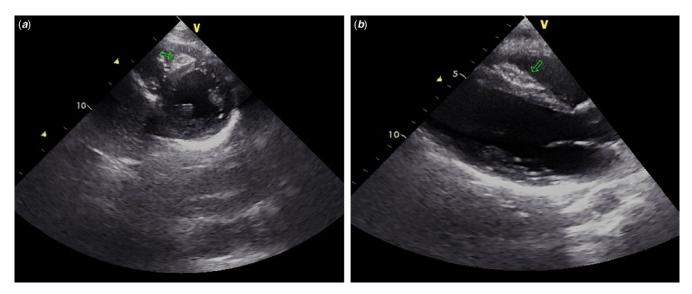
Echocardiografic view of the mass lesion, (a) short axis, (b) long axis.
